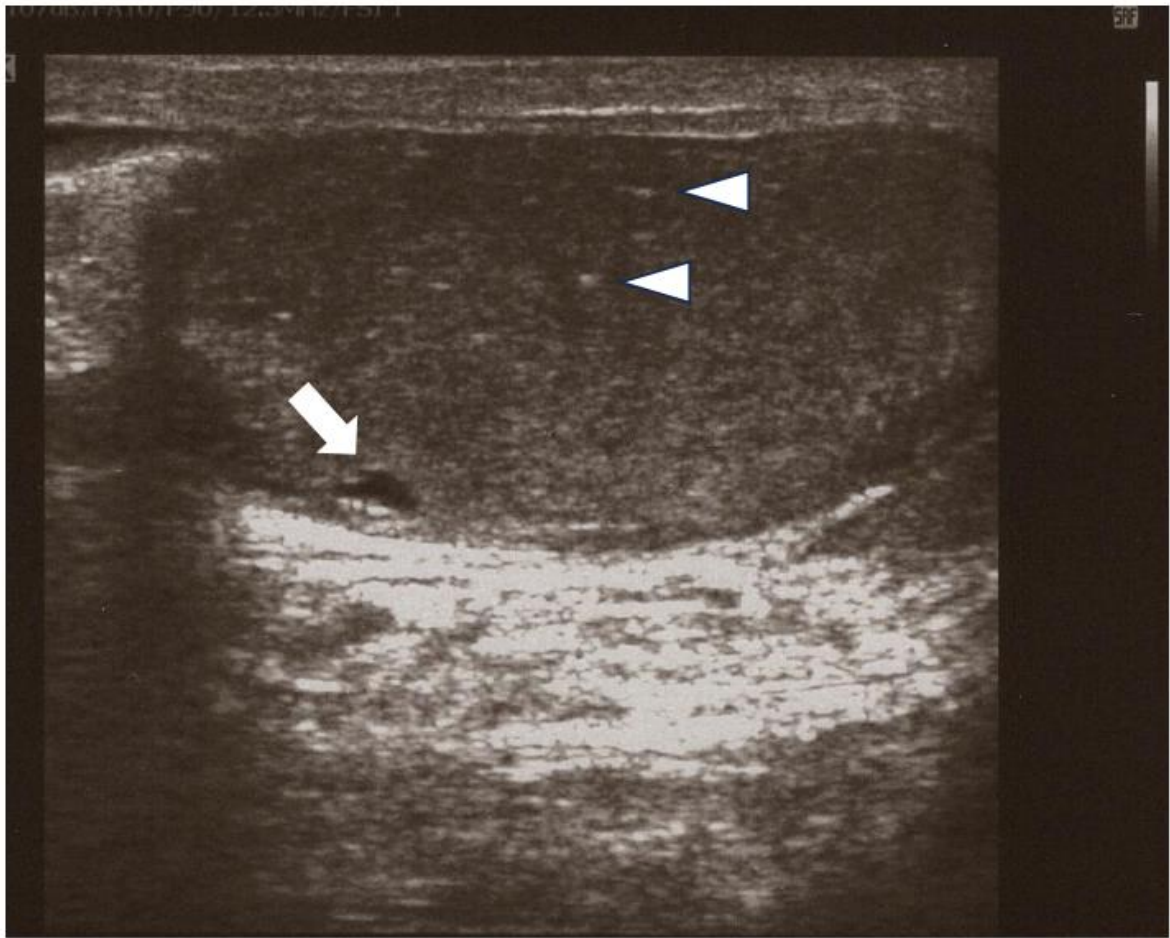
Ultrasonography of the right testis. A 2-mm subcapsular cyst is present beneath the tunica albuginea. Numerous microliths are seen within the testicular parenchyma.
